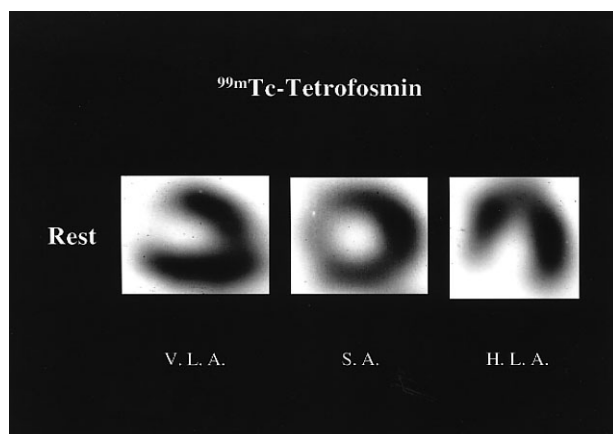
^{99m}Tc-tetrofosmin myocardial SPECT. ^{99m}Tc-tetrofosmin myocardial SPECT showed mildly reduced uptake from the anteroapical region to the apex on the rest images.
